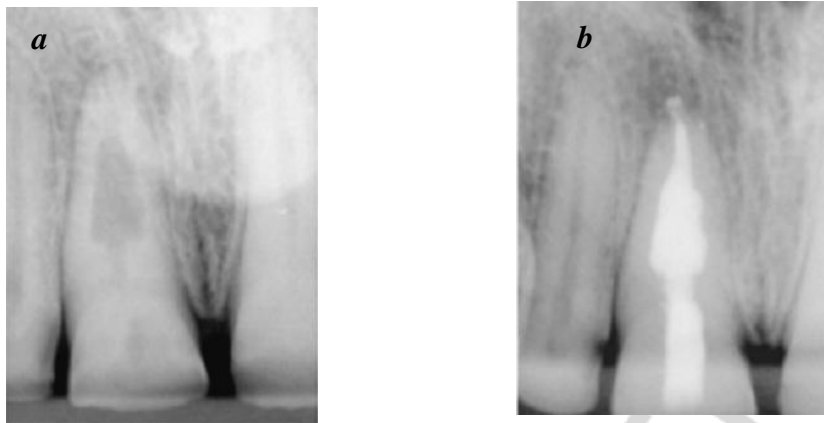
Pre-operative (a) and post-operative (b) radiograph of the patient with the internal inflammatory root resorption in the middle root of the left upper central incisor. A final radiograph shows the root canal and the internal resorption filled with gutta-percha and sealer using warm vertical condensation
